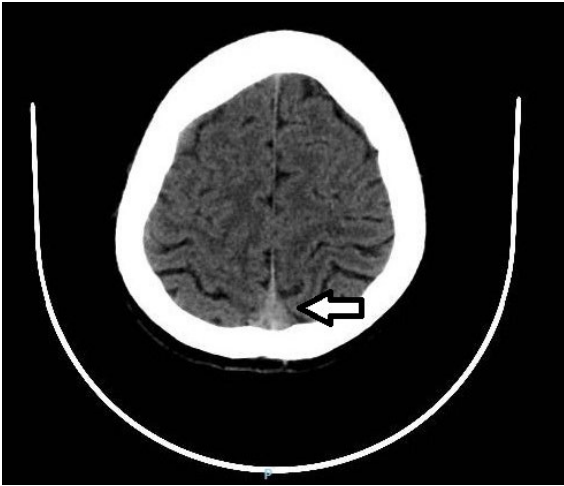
Superior sagittal sinus thrombosis – intrasinus thromb – Computed Tomography
